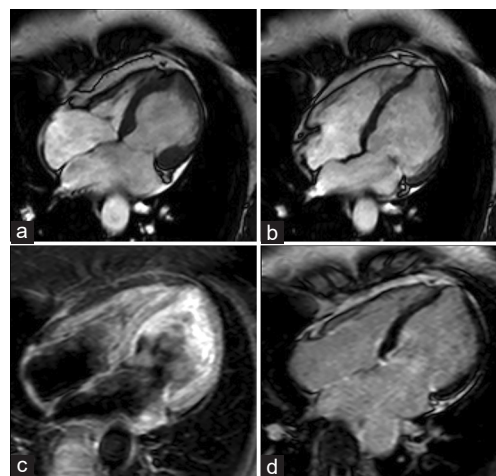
Cardiac magnetic resonance imaging performed at patient's hospital admission. Balanced steady-state free precession cine-images performed along the four-chamber view in end-systole (a) and end-diastole (b) show circumferential akinesia of midventricular segments. T2-weighted short-time inversion recovery (c) and T1-weighted phase-sensitive inversion recovery images (d) performed along the same plane, respectively, showing diffuse increase of myocardial signal and no evidence of late gadolinium enhancement
